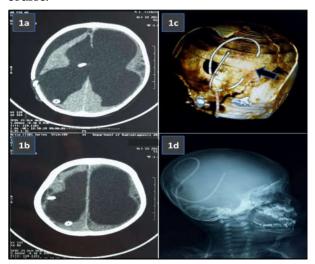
(a & b) NCCT head showing proximally migrated V-P shunt Chamber in the right occipital horn of lateral ventricle, (c) 3D-NCCT head & (d) X-ray skullshowing Intracranial location of the chamber
